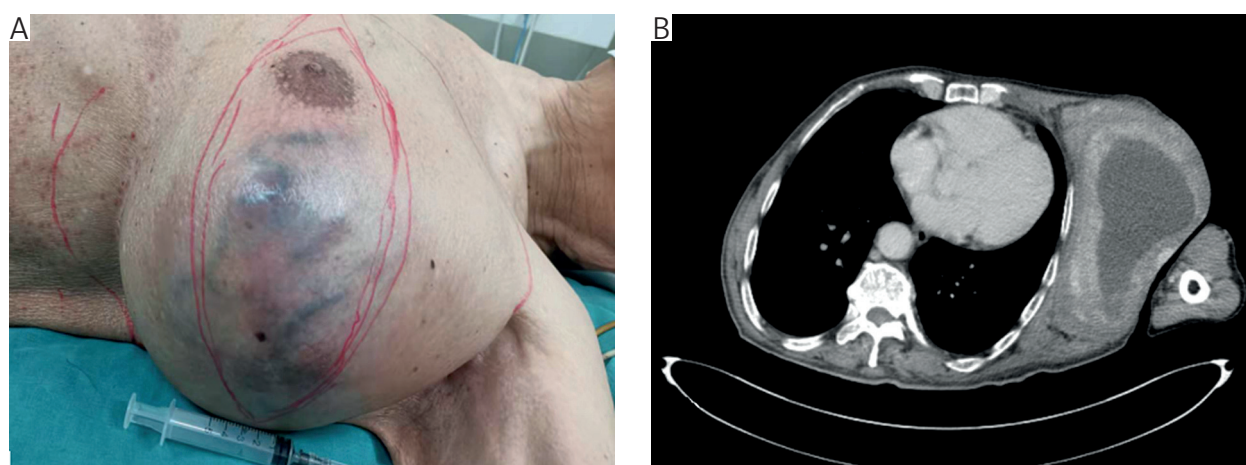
A) Side view of the giant tumor. B) The computed tomography image of cross-sectional about tumor's relationship with muscle
